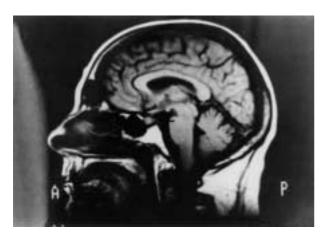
T_1 -weighted magnetic resonance imaging (MRI) examination of the hypothalamic and pituitary regions demonstrated no masses in the hypothalamic region and absence of hyperintense signal in correspondence to the posterior pituitary gland, suggesting hypoatrophia, possibly due to a stalk damage (arrow).
